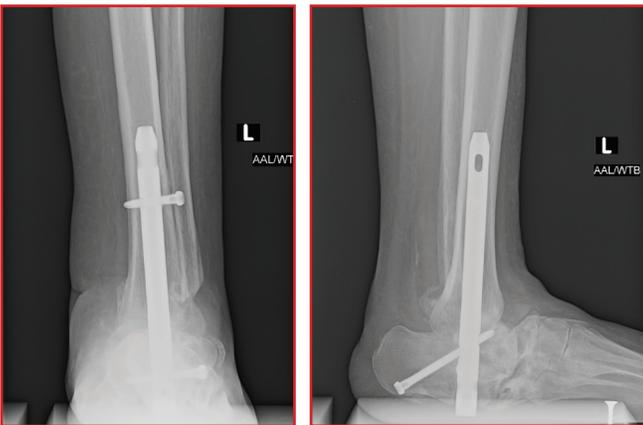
Postoperative AP and lateral x-rays with ankle realigned and nail in position resulting in stable plantigrade foot at 6 months.
